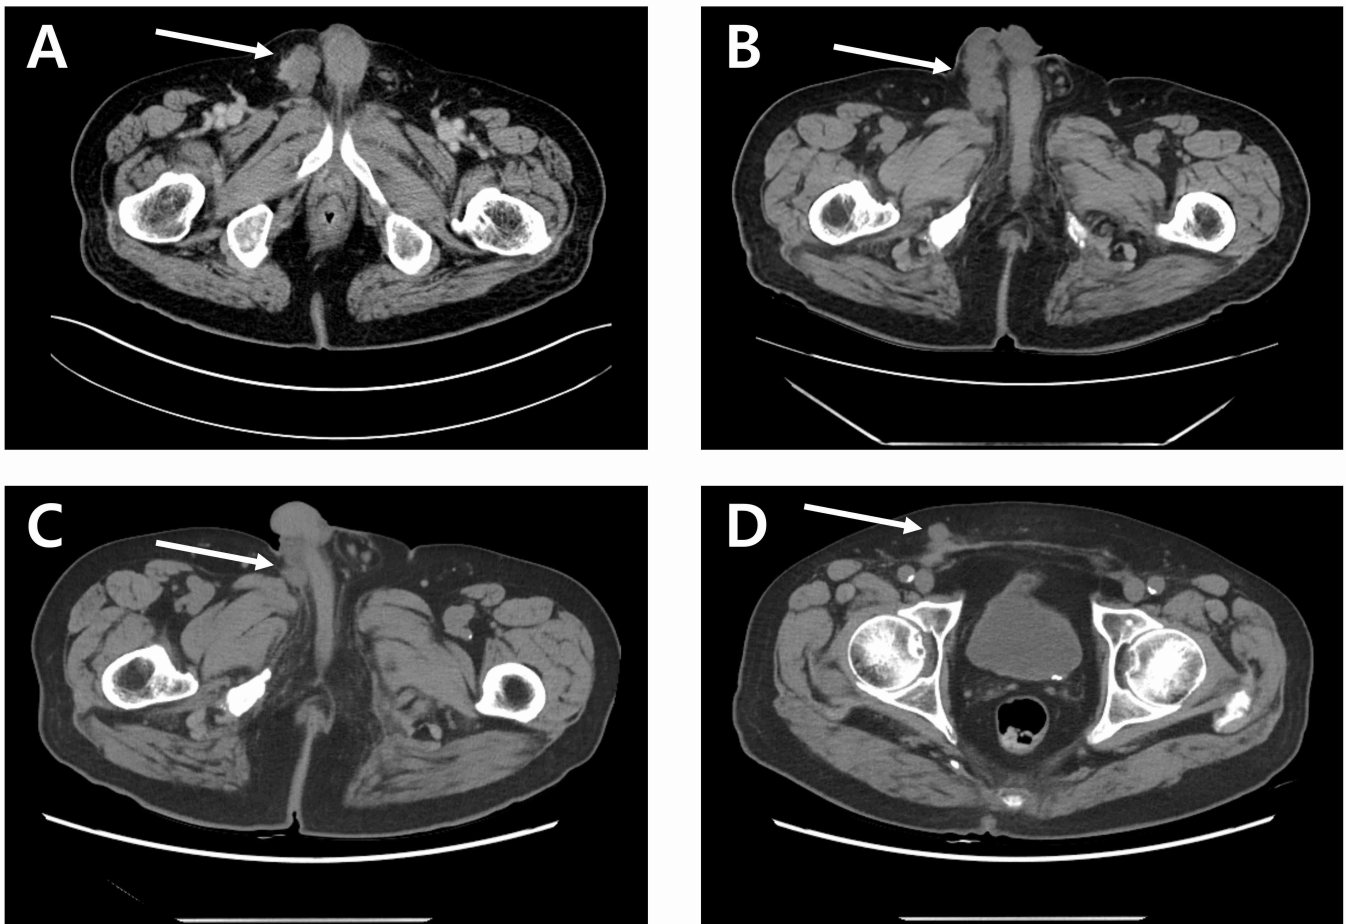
Computed tomography scan images. Recurrences of paratesticular malignant mesothelioma in (A) October 2021, (B) April 2022, (C) November 2022 and (D) February 2023.
